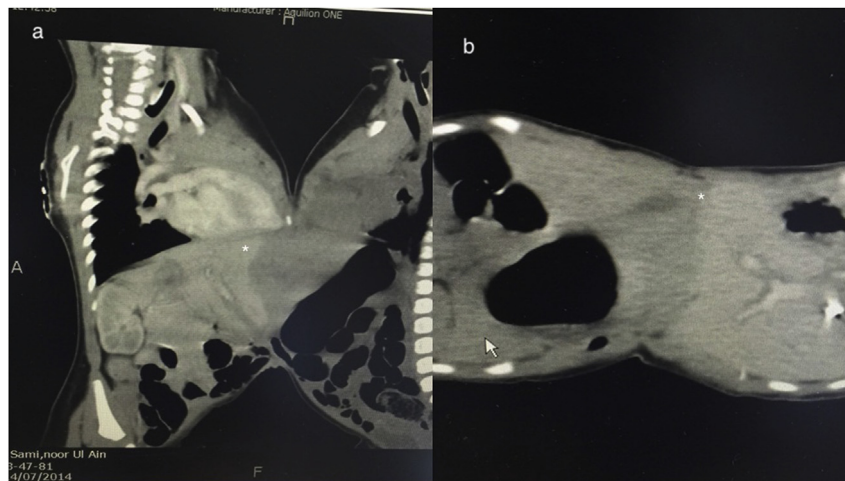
Contrast CT Scan showing fusion of livers and cleavage line.
